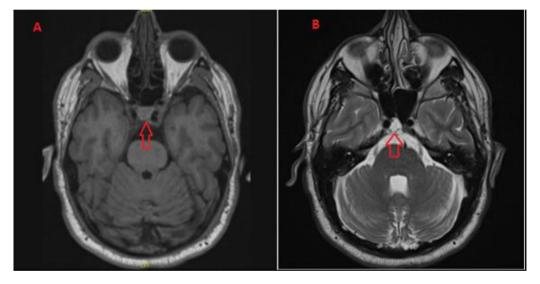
Follow-up MRI study performed 4 years later, showing the same lesion (red arrow) with identical size and characteristics on T1-weighted (A) and T2-weighted sequences (B). We observed no bone destruction or other signs of malignancy.
